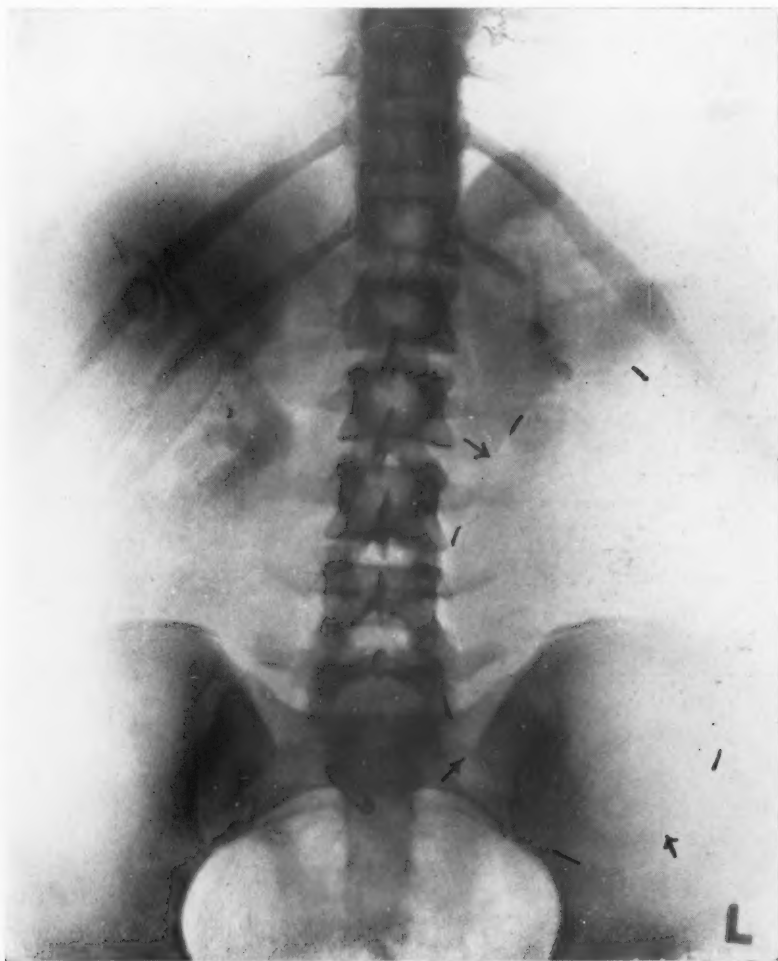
X-ray plate of the abdomen in Case II, after the administration of skioidan. Note the displacement upward of the left kidney by the large mass in the left abdomen, which, in spite of its very thin wall, casts sufficient shadow for a great deal of its outline to be defined clearly.
